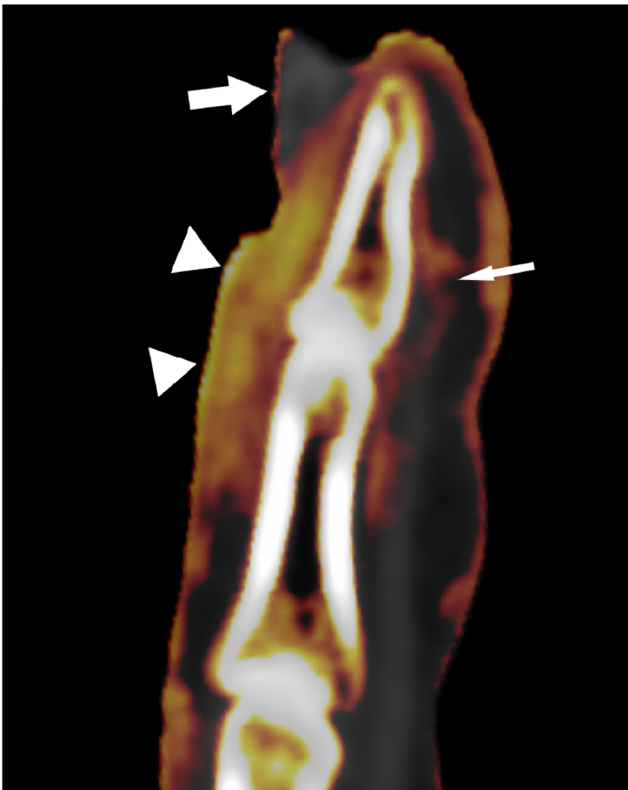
Diffuse inflammatory lesion in the DIP joint. A 42-year-old patient with psoriatic arthritis (PsA) and marked nail deformity (arrow). Dual-energy computed tomography (DECT) iodine map shows swelling and enhancement along the extensor tendon at the distal interphalangeal (DIP) joint, suggesting extensor peritendinitis and enthesitis in the tendon attachment site at the distal phalangeal base (arrowhead). Abnormal enhancement spreads into the nail bed (thin arrow). Flexor tendon enthesitis and tenosynovitis are also present
